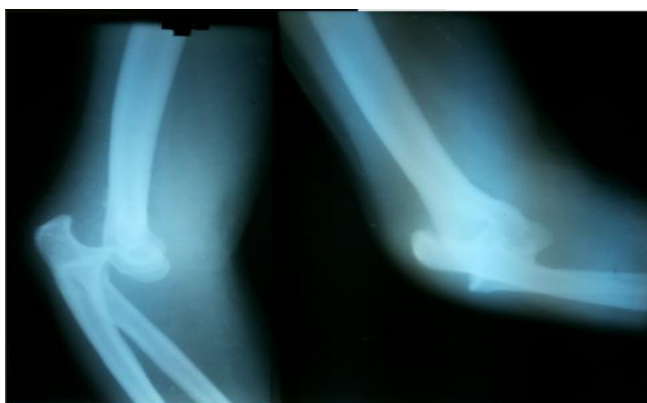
Anteroposterior and lateral radiographs of patient 2 demonstrating chronic elbow dislocation 12 weeks after the injury
